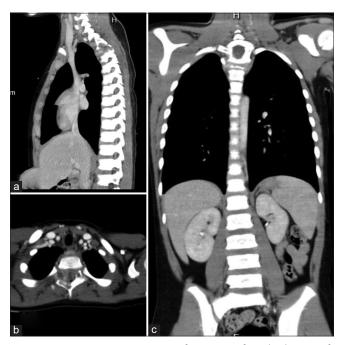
Pre-operative computed tomography; (a-c) sagittal, coronal, and axial views of an expansile osteolytic lesion involving the T3 right lamina, pedicle with severe vertebral body collapse, and loss of normal kyphosis.
